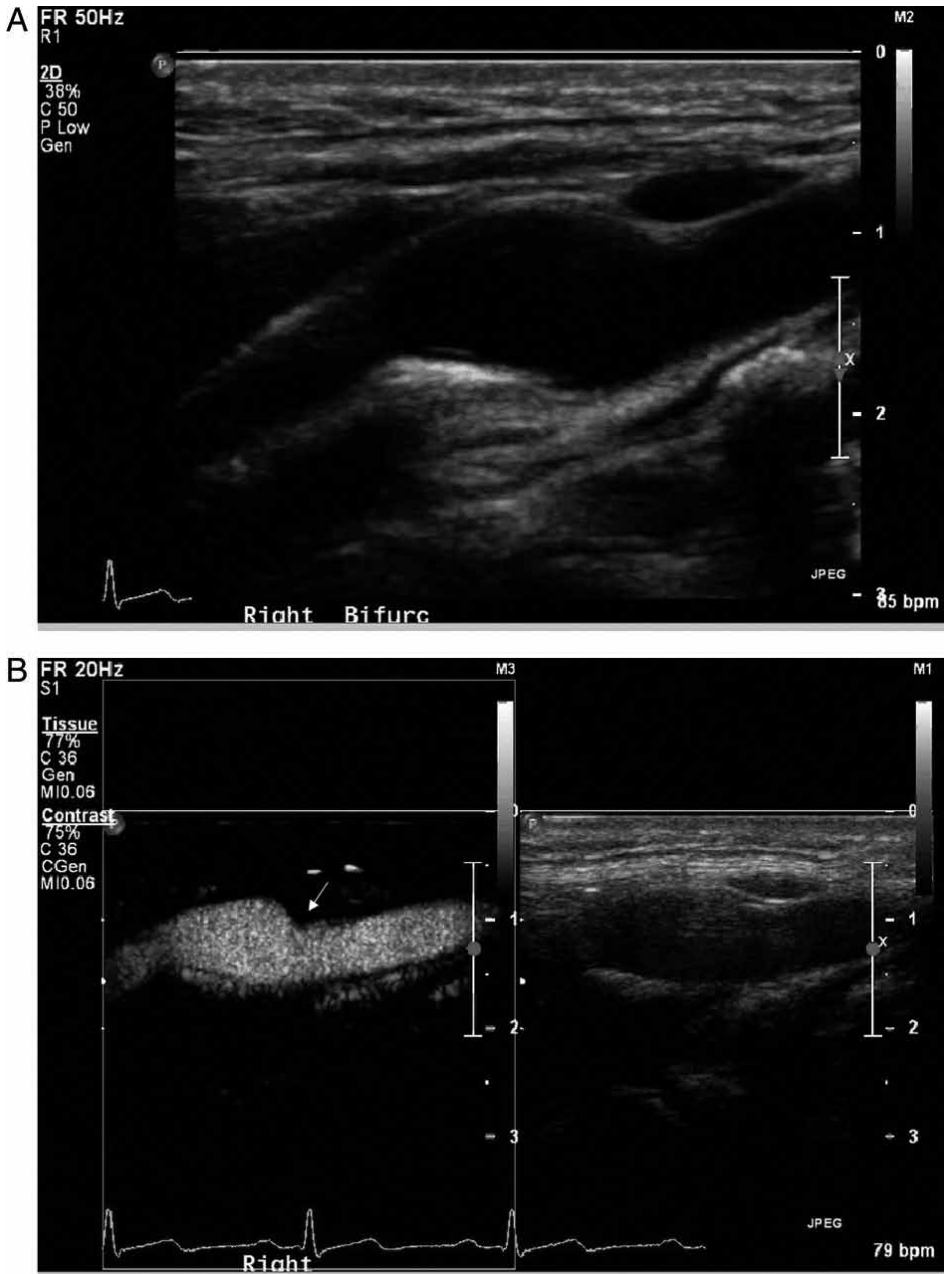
Assessment of subclinical atherosclerosis using standard carotid ultrasound and CEUS. (A) B-mode still frame of the right carotid artery. On the image, the distal CCA, bifurcation, and proximal ICA are visible (from right to left). No atherosclerotic plaques were detected. (B) Corresponding combined B-mode and CEUS still frame. An atherosclerotic plaque is visible on the contrast-enhanced still frame. It is located in the distal CCA and bifurcation (white arrow).
